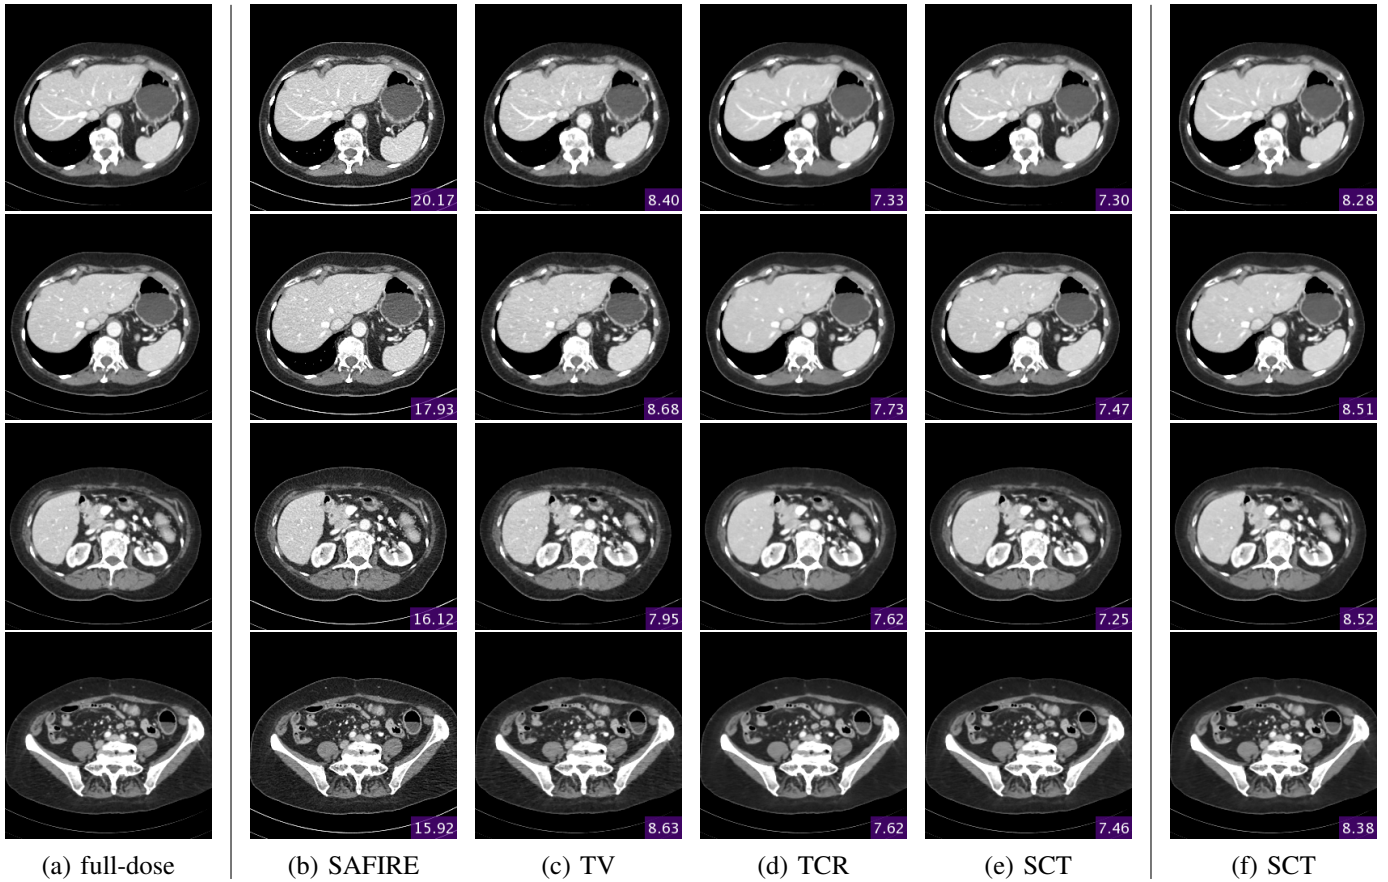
Representative slices for reconstruction of in vivo abdominal test data for low-dose CT. The purple boxes report RMSE values. (a) Target: TV ( $\beta = 1$ ) reconstruction of the fully-sampled high dose data, (b) SAFIRE [2] using 1/4 dose, (c) TV ( $\beta = 1.75$ ) reconstruction using 4-fold undersampling, (d) VN for TCR reconstruction using  $T = 10$  steps and 1/4 dose, (e) VN for SCT reconstruction using  $T = 10$  steps and 4-fold undersampling, and (f) VN for SCT reconstruction using  $T = 10$  steps and 6-fold undersampling.
